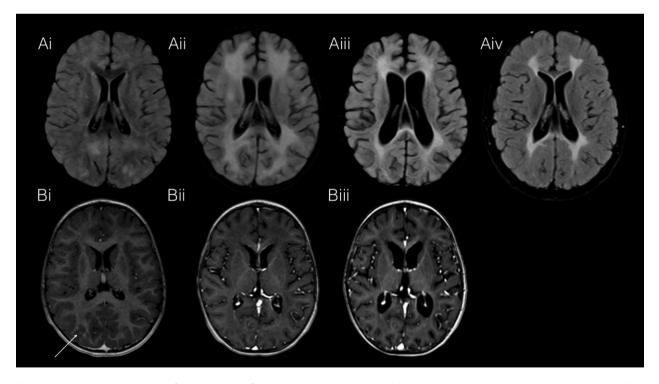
Cerebral MRI evolution of white matter inflammation and atrophy. (A) Axial MRI, FLAIR sequence. (B) Axial MRI, T1 post-gadolium. Arrow indicates area of gadolinium enhancement. (i) initial presentation; (ii) 16 days after presentation; (iii) 63 days after presentation; (iv) 3 years after initial presentation.
